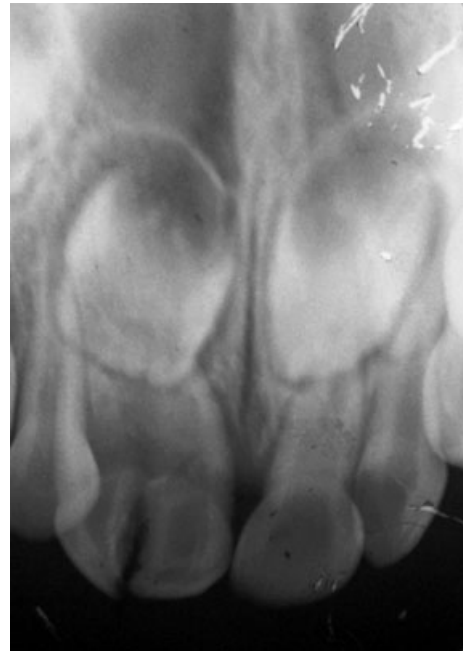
Intra-oral periapical radiograph showing crown root fracture in the mesial part of the 'double tooth'.
